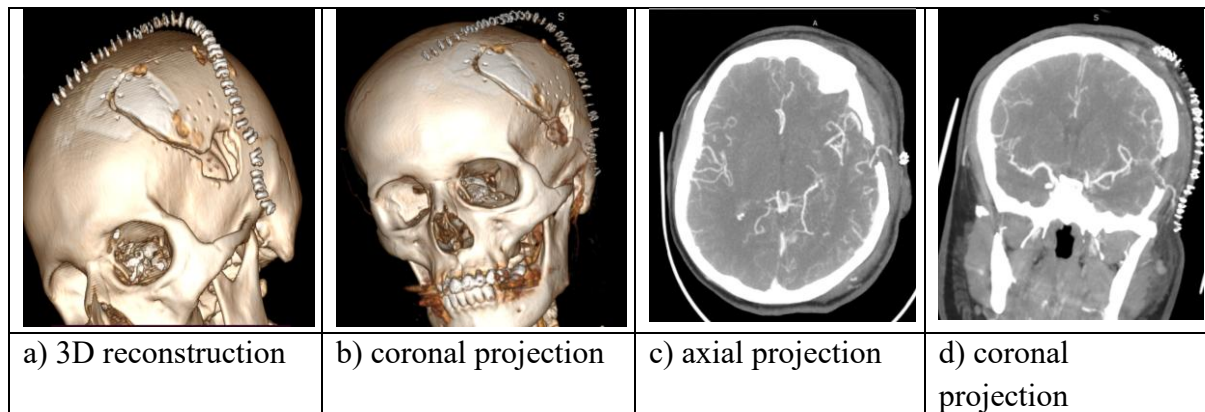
CT angiography of the cerebral vessels on postoperative day 2 after extra-intracranial microanastomosis.
